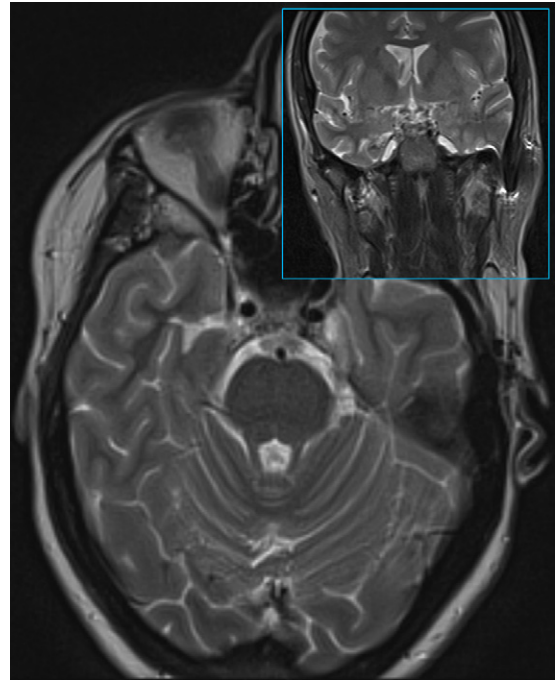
Axial magnetic resonance image (MRI) four months after arthroscopy showing resolution of high signal areas. Inset: coronal MRI confirming resolution of the signal.
